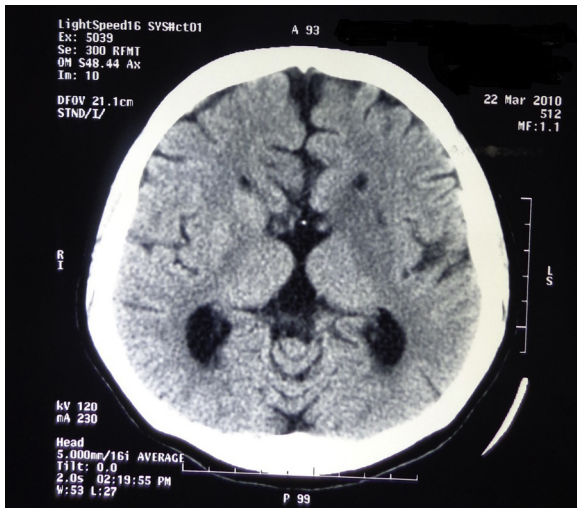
CT scan showing hypodensity in the left ganglionic capsular region and subcortical parietal region along with absence of the corpus callosum.
